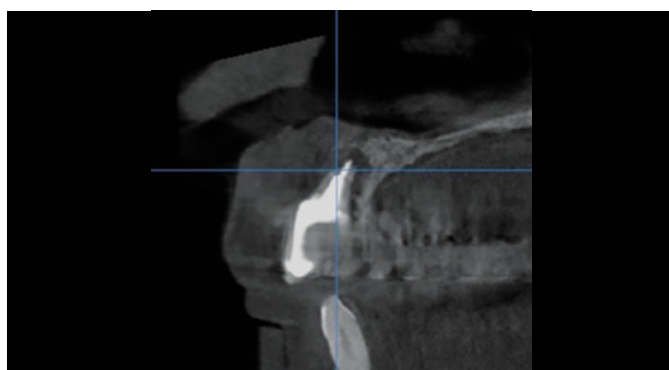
CBCT cross-section no 11
